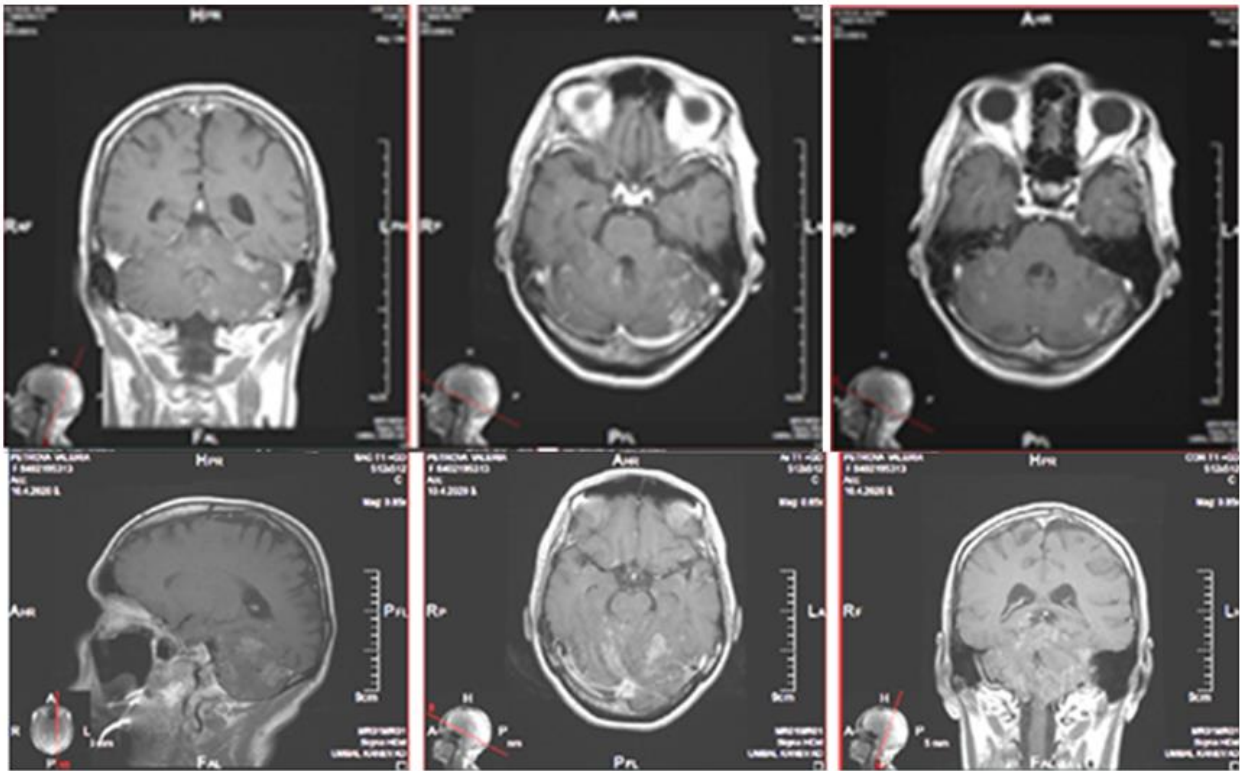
SAG T1 FLAIR+C, AX T1 FLAIR+C, COR T1 FLAIR+C MR postcontrast images showing hyperintense contrast-enhancing leptomeningeal brain lesions, mainly infratentorial in the cerebellum and medulla oblongata, with mild compression of the brainstem.
